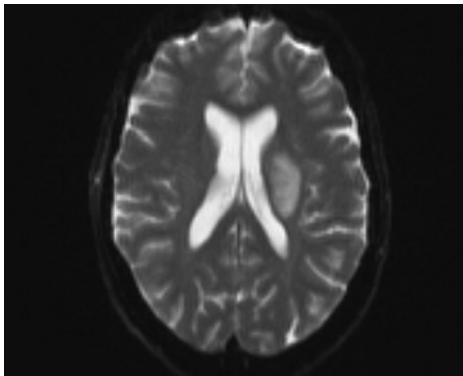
Magnetic resonance imaging showing area of left basal ganglia infarct.
